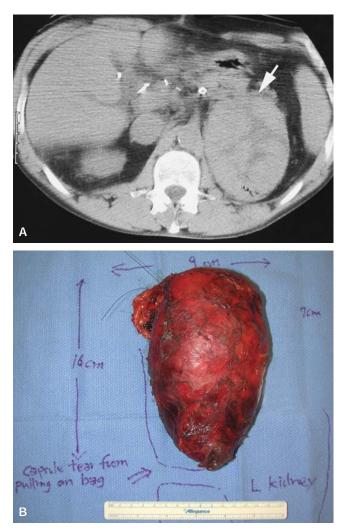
A 62-year-old man, who 3 years ago had a liver transplant because of end-stage liver disease owing to hepatitis C, had a computed tomographic (CT) scan because of left flank pain. *A*, An abdominal CT scan showed a 9 cm left adrenal tumor (*white arrow*). Fine-needle biopsy of this lesion was most consistent with a metastatic hepatoma. Other studies, including positron emission tomographic scan, showed no other obvious metastasis. He underwent a diagnostic laparoscopy, which showed no obvious other lesions and had a laparoscopic hand-assisted left adrenalectomy. *B*, The pathology showed a 16 cm × 9 cm × 7 cm metastasis from a hepatoma.
